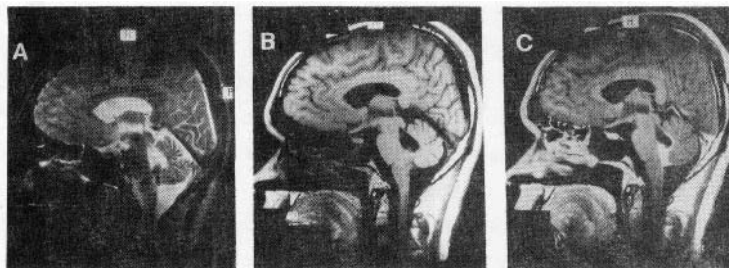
Intraventricular healing cysticercosis with ependymitis. T2-weighted sagittal section (a) shows evidence of a hypointense area in the inferior part of fourth ventricle with mildly dilated fourth ventricle. On T1-weighted image (b) the lesion appears isointense. Postcontrast image (c) shows enhancement of the lesion along with roof of fourth ventricle suggestive of ependymitis.
